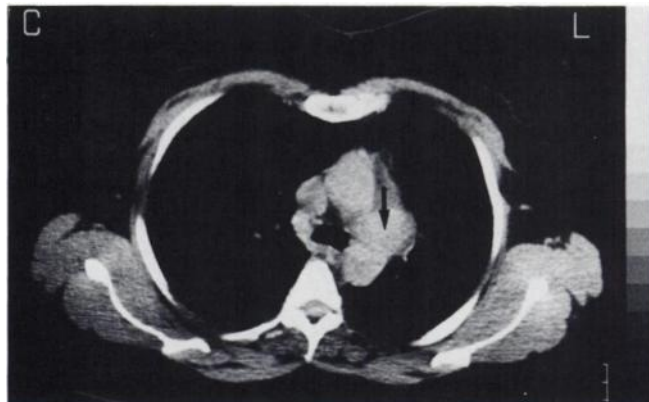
CT scan of the thorax shows a mass adjacent to the inside bend of the aortic arch.
